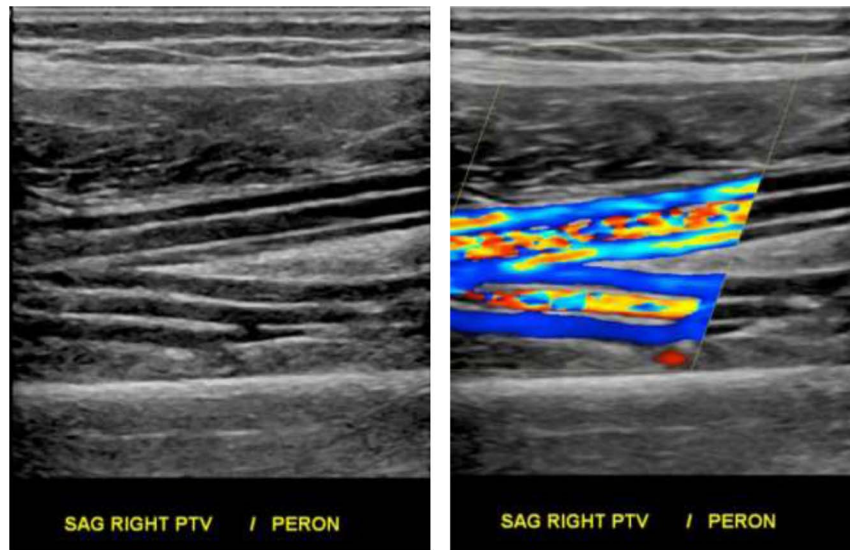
Deep system. Sagittal view of posterior tibial veins and peroneal veins at calf level. In gray scale, a group of 3 anechoic vessels can be seen, as the pair of veins accompanies the corresponding artery. Color Doppler shows that the middle vessel corresponds to the artery in each case.
